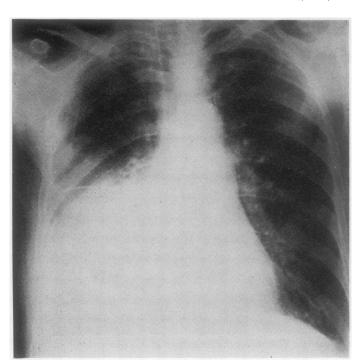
Case 6. Plasma cell granuloma. Posterior-anterior radiograph of mass in right lung.
